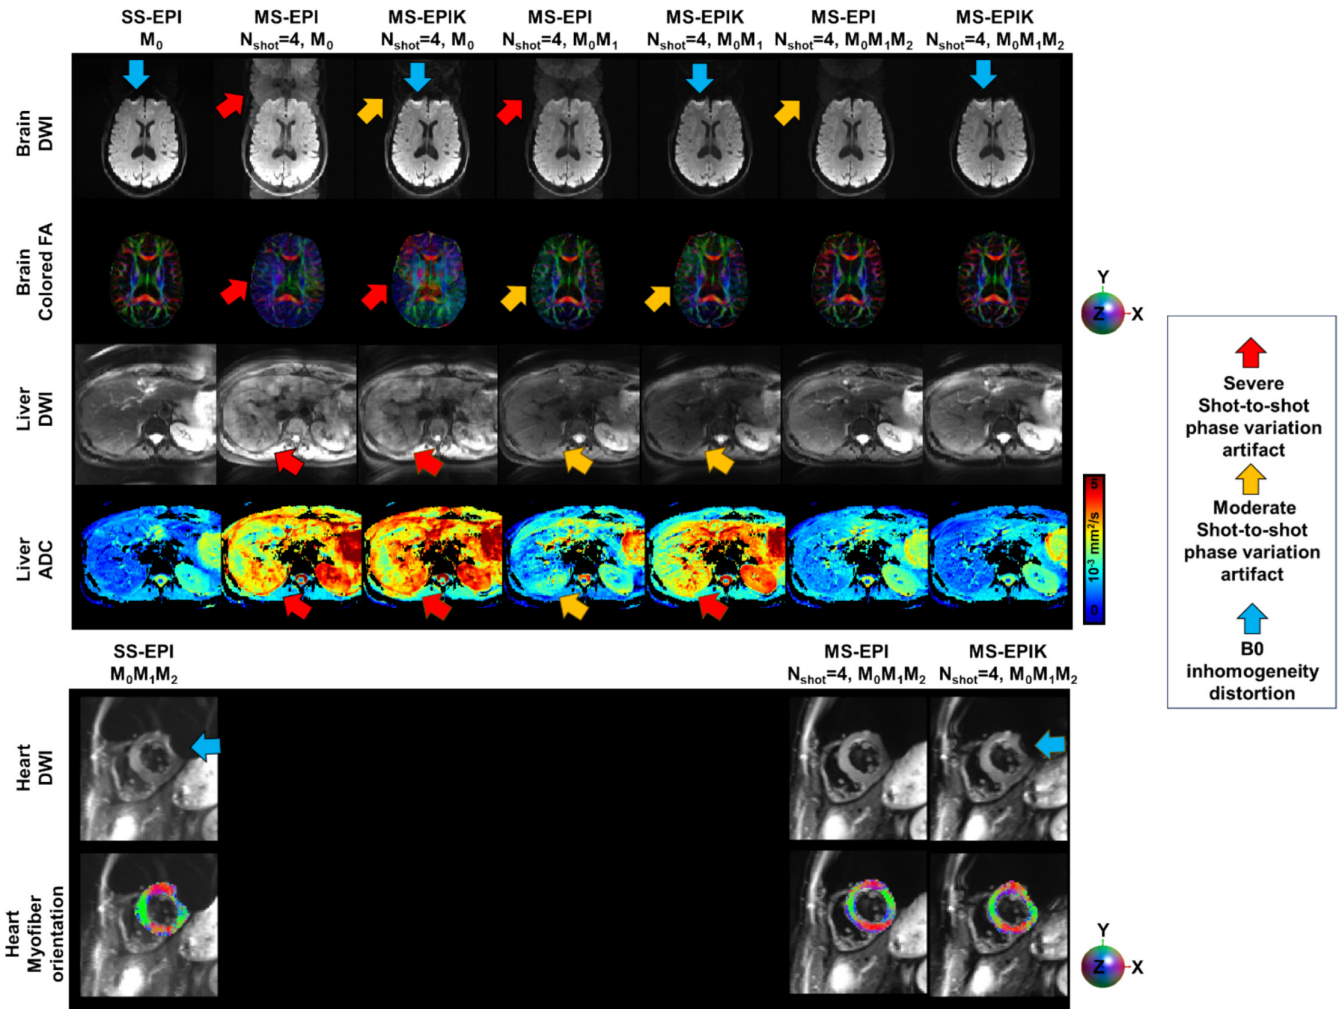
Example of in vivo images in one volunteer of the brain, liver, and heart with a naïve reconstruction for the non-motion compensated (M_0) and motion compensated (M_0M_1 and $M_0M_1M_2$) diffusion encoding waveforms and for the single-shot EPI (SS-EPI) and multi-shot EPI (MS-EPI) and EPIK (MS-EPIK) acquisitions. Diffusion-weighted images (DWI) are shown for each organ as well as the colored fraction of anisotropy (FA) for the brain, Apparent Coefficient of Diffusion (ADC) for the liver, and the primary Eigen orientation (E1 or aggregate cardiomyocyte orientation) in the heart. SS-EPI are acquired without motion compensation (M_0) for the brain and liver and with second-order motion compensation ($M_0M_1M_2$) for the heart.
